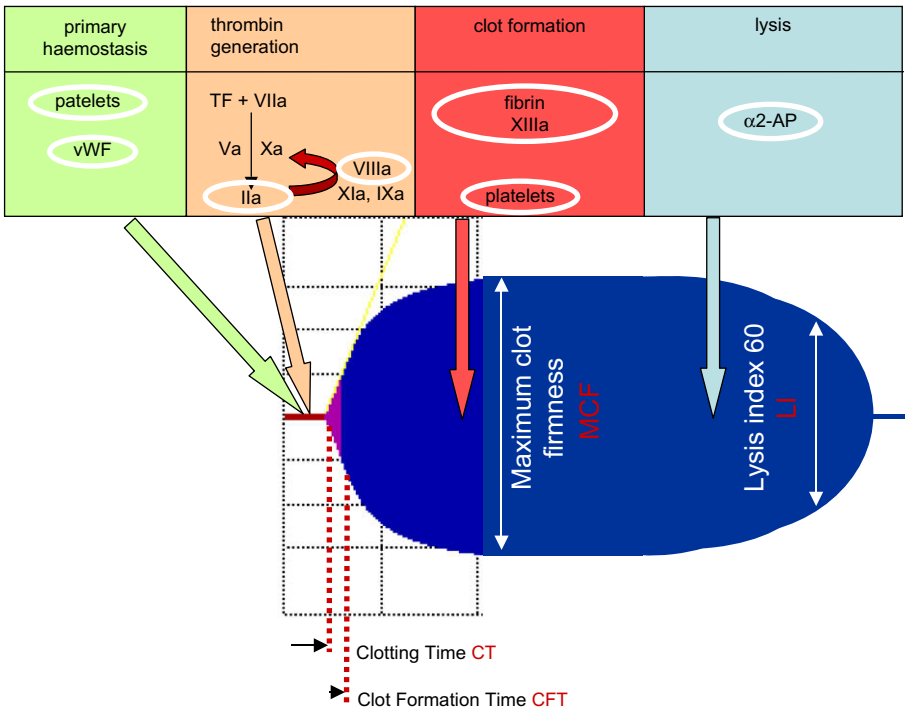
Thrombelastometric trace and parameters. Clotting time (CT in s), clot formation time (CFT in s), maximum clot firmness (MCF in mm) and lysis index at 60 min (LI in %). White circles indicate targets for anticoagulant effects of synthetic colloids (dextran > slowly degradable hydroxyethyl starch > rapidly degradable hydroxyethyl starch = gelatin). vWF, von Willebrand factor; TF, tissue factor; t-PA, tissue plasminogen activator; α 2-AP, alpha 2-antiplasmin.
